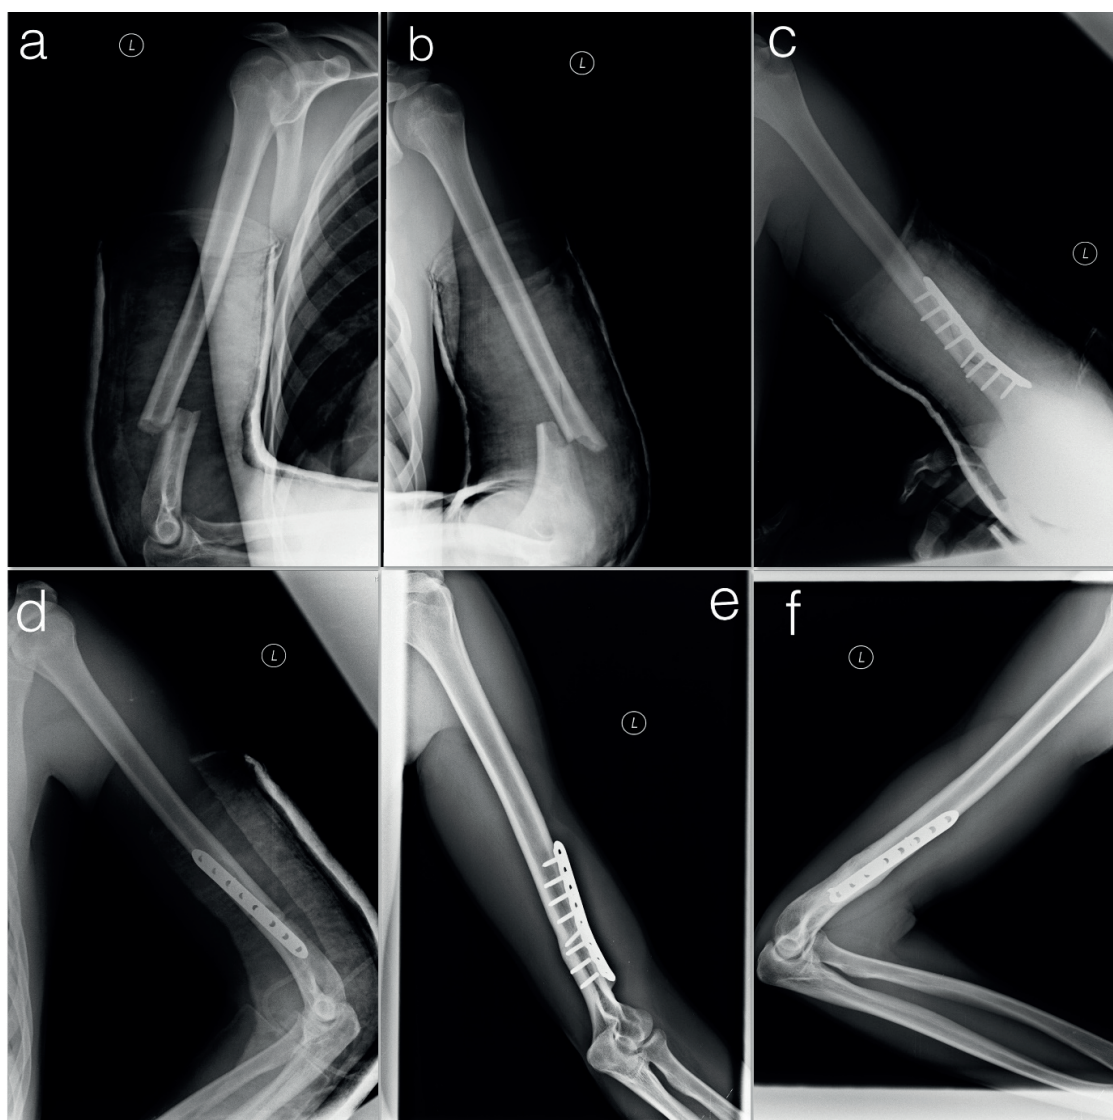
X-ray of distal 1/3 humerus fracture. Pre-operative (a, b), post-operative (c, d) and after eight months from the surgery (d, e)
